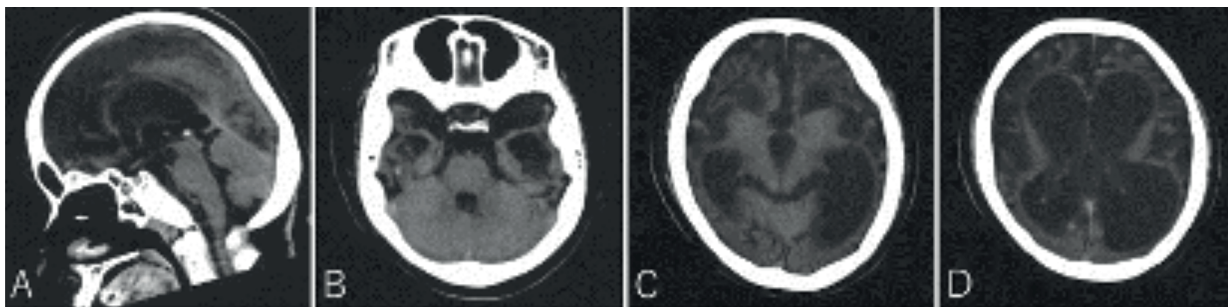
At 9 years of age, the patient's brain CT revealed severe cerebellar cortex atrophy compared with the preserved cerebellum. Leukoencephalopathy and ventricular enlargement can also be observed
